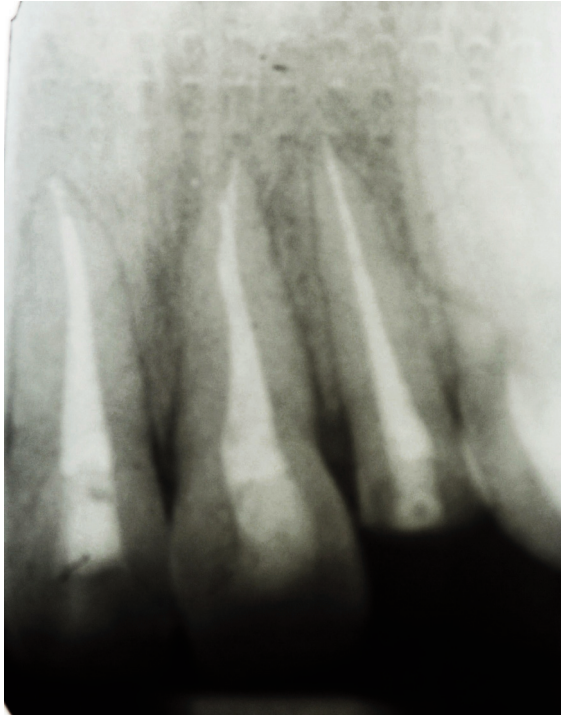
Periapical radiograph after endodontic treatment when the splint was removed.
